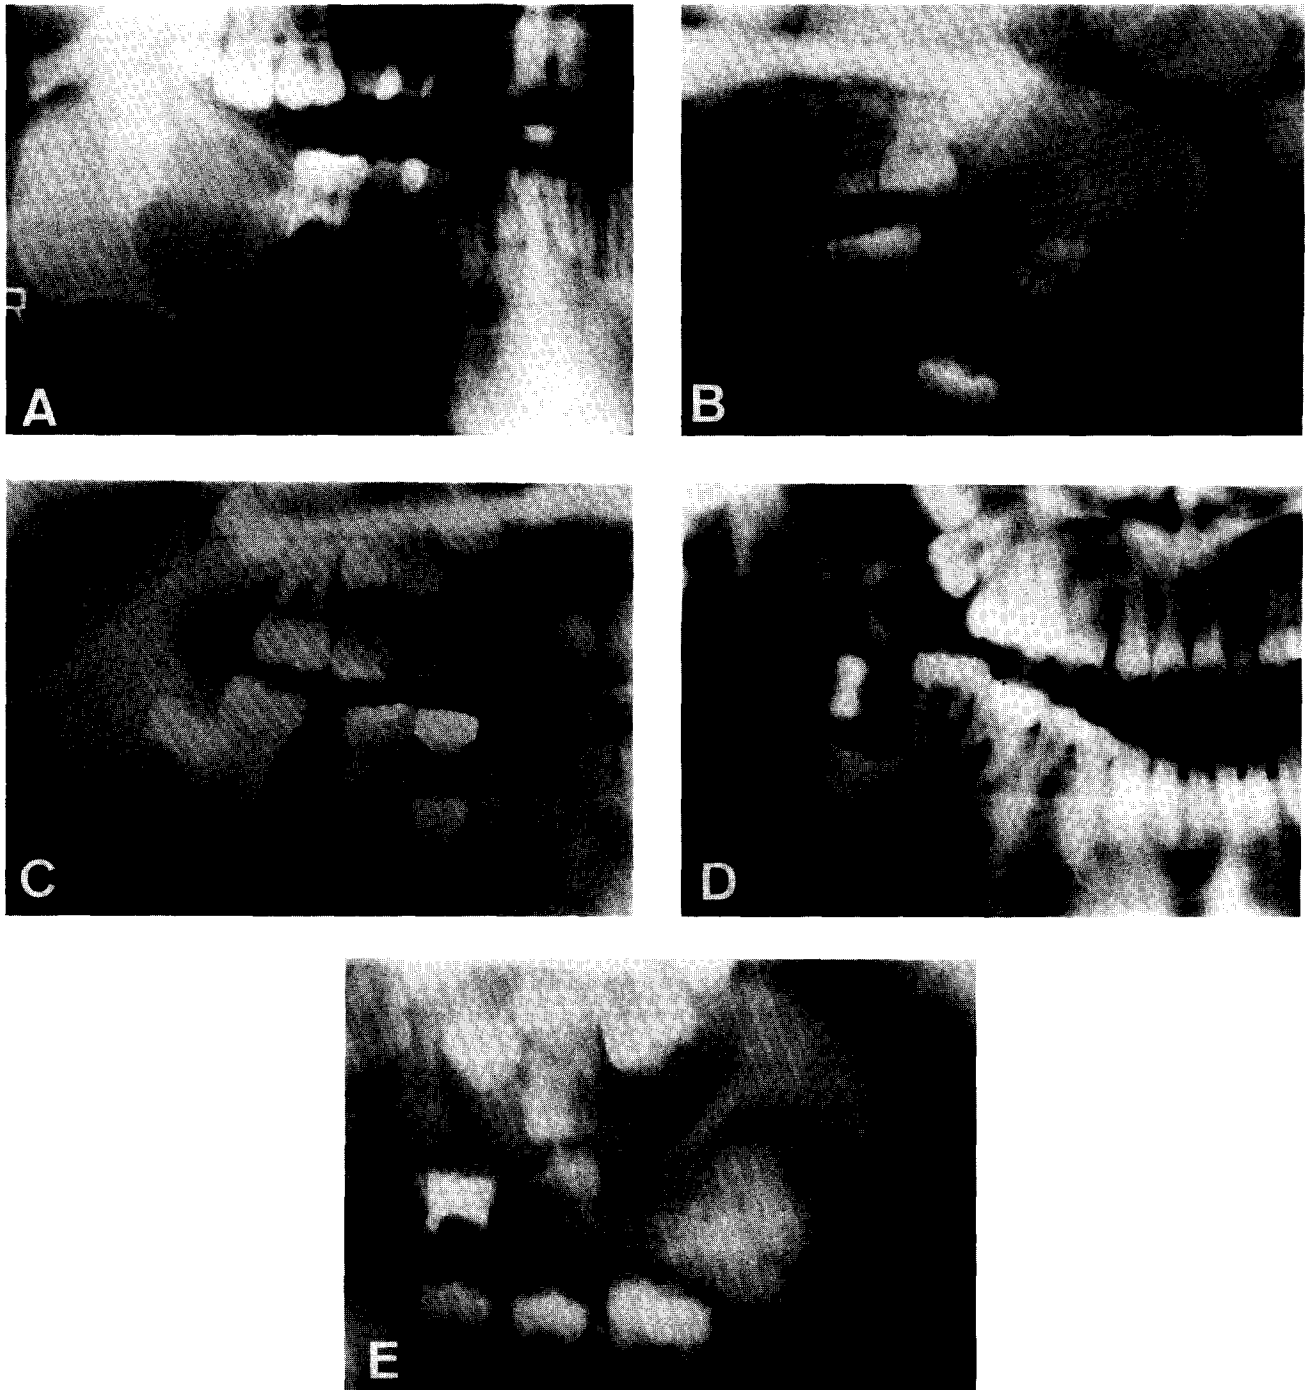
X-ray pictures of mixed odontogenic tumours. (A) Case 1, multicystic radiolucent shadow in the right mandible. This lesion includes 2nd and 3rd molar teeth and the roots of 654 are resorbed. (B) Case 2, expansive radiolucent lesion including many calcified materials is found at the left mandible. The distal root of 7E is resorbed and the 1st molar is dislocated. (C) Case 3, radiolucent lesion is found between the roots of 6 and 7E causing the diasthema. The tooth germ of 5 is not visible and the root of 7E is slightly resorbed. (D) Case 4, localized cystic lesion including the crown of 8 is seen. The root of 8 is not yet formed. (E) Case 5, cystic lesion including irregularly calcified substance is observed at the left mandible. The tooth germ of 6 is dislocated and those of 78 are not visible.
